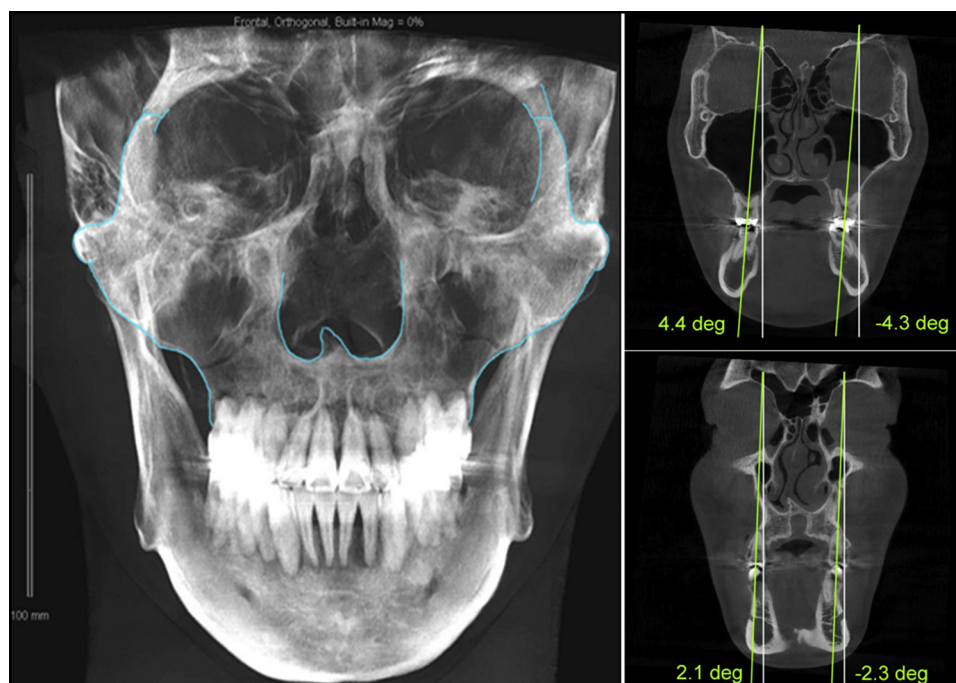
Final posteroanterior orthogonal cephalometric radiograph and CBCT axial cuts showing initial dentition angulation.
